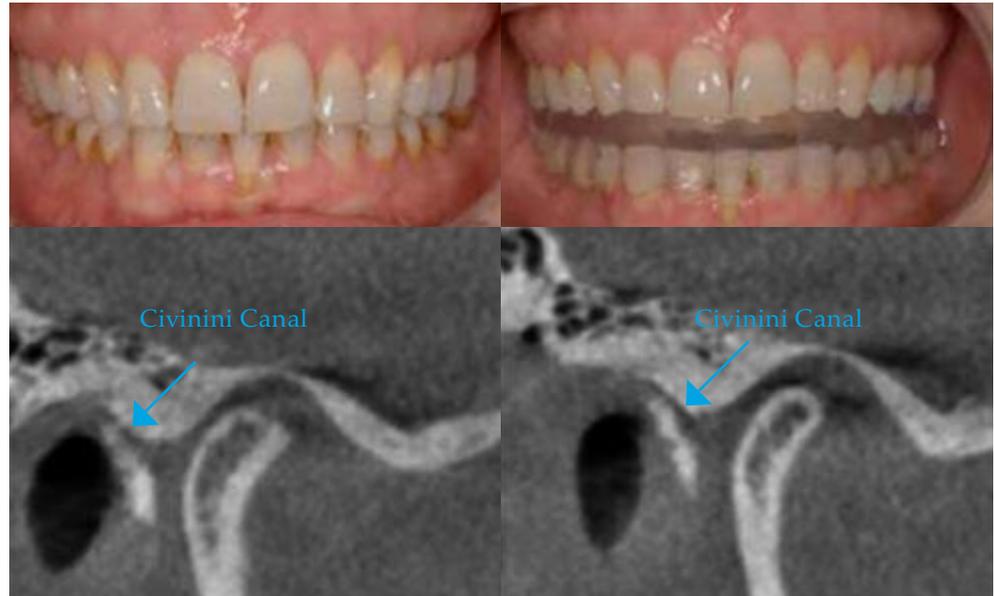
A retroposed condylar position compresses the retrodiscal tissue by increasing the intracapsular tension and the differentiated fibrous structures that connect the middle ear with the TMJ which are the malleolar disc ligament (MDL) corresponding to the posterior upper fibers of the retrodiscal tissue and the anterior malleolar ligament (AML) which is an extension in the tympanic cavity of the sphenomandibular ligament that penetrate into the middle ear through the Civinini canal here clearly visible (red arrow). In the CT scan of the TMJ, the retroposed condyle in this young patient is highlighted, reports tinnitus, muffling and pain in the ear and tension in the cervical musculature and shoulder girdle.
